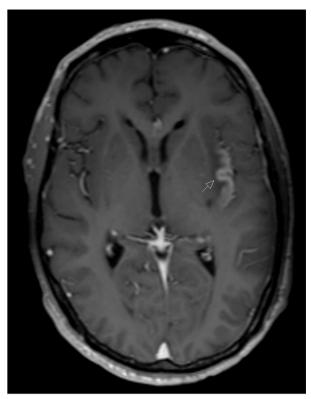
First axial contrast-enhanced T1-weighted magnetic resonance imaging (MRI), showing enhancement along the left insular lobe, particularly of the insular cortex (arrow).
